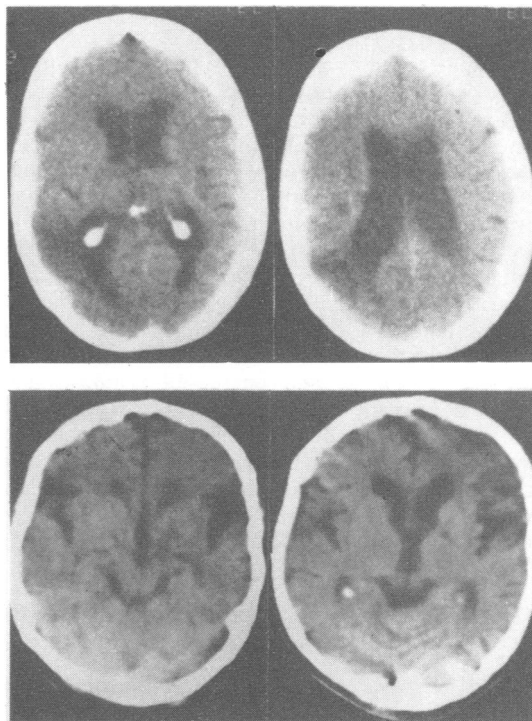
Figure (A) (above) CT scan. Selective cuts showing low attenuation in the right temporo-parietal region indicative of infarction. The ventricular system is dilated. (B) (below) CT scan. Selective cuts showing cerebral atrophy and areas of low attenuation indicative of infarction in both temporal and the left frontal regions. Further cuts (not shown) show left parietal involvement.
